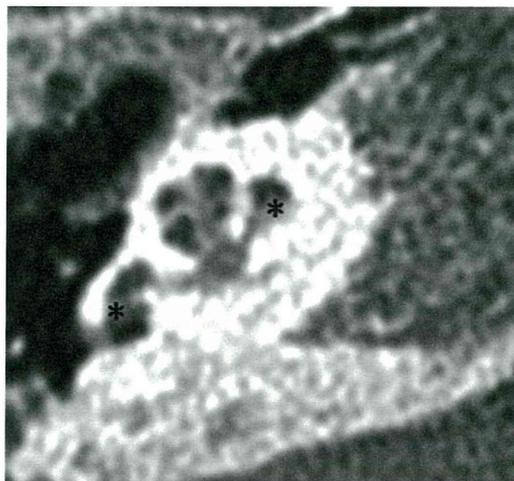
A CT scan image of right ear at the second cochlear implantation. The asterisks indicate ossification of the scala tympani in the basal turn of the cochlea.
